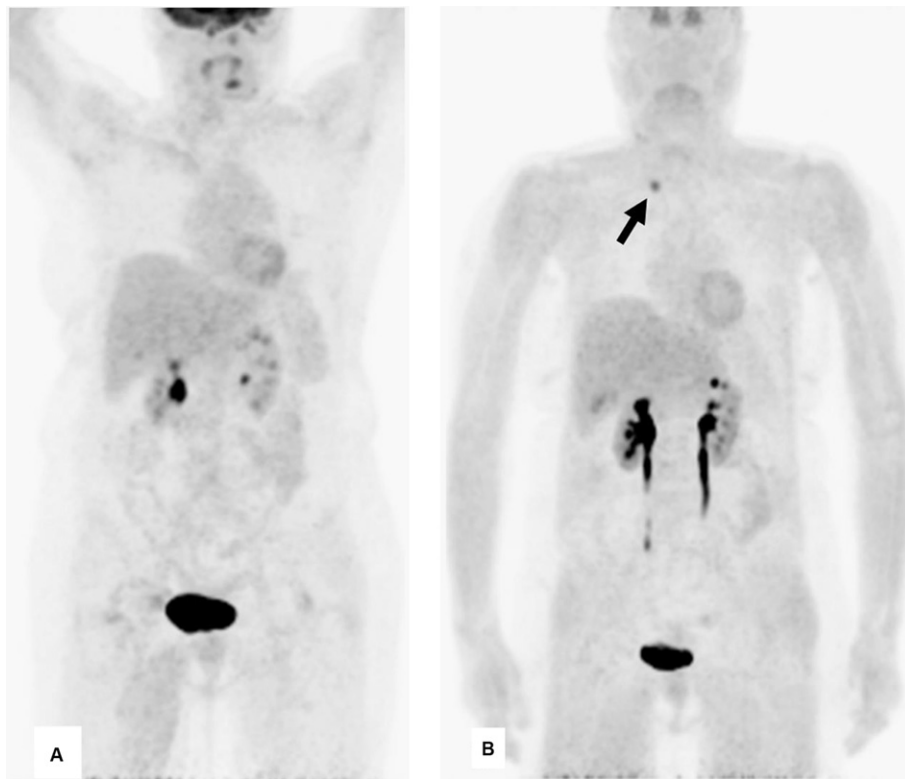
^{18}F -FDG PET (A) and ^{18}F -DOPA PET (B) maximum intensity projection images in a patient with recurrent medullary thyroid carcinoma based on increased serum calcitonin levels. ^{18}F -FDG PET was negative whereas ^{18}F -DOPA PET showed an area of increased radiopharmaceutical uptake corresponding to a right laterocervical lymph node (arrow) suspicious for tumor relapse (diagnosis confirmed by surgery).
